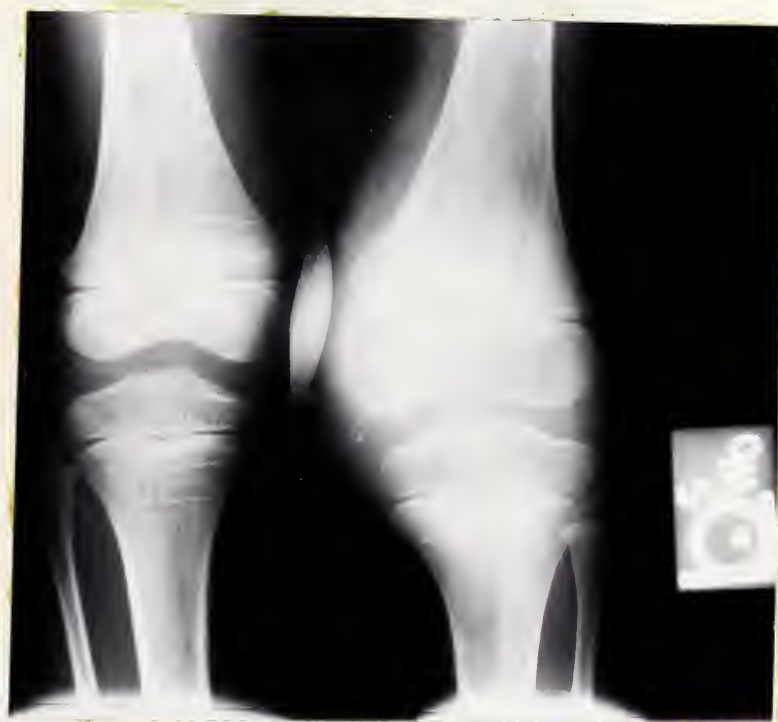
Case 1: Roentgenogram of knees: bones of the left knee are larger than that of the right.
